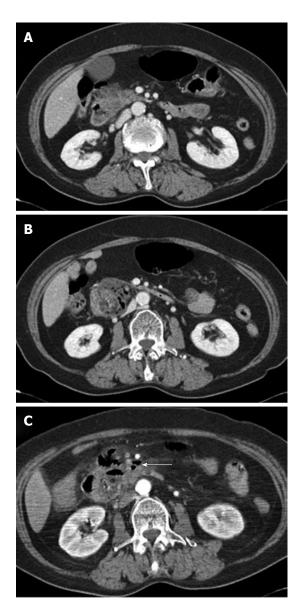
Abdominal computed tomography findings. A: The pancreas head showed swelling with irregular contour of the pancreatic margin and mild peripancreatic infiltration; B: There is a 5 cm size subtle rim enhancing mass with air bubbles, indicating acute diverticulitis in the second duodenal portion or air forming abscess of the pancreatic head; C: After nine days, a few extraluminal air bubbles (arrow) suspicious for microperforation were found.
